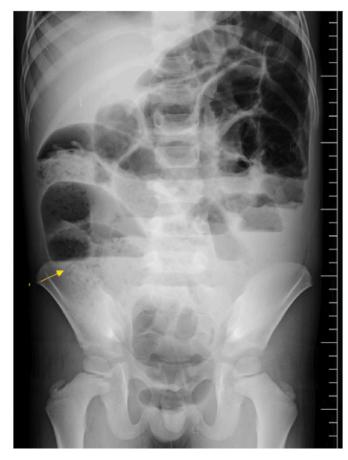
Multiple loops of dilated bowel can be seen throughout the abdomen on abdominal radiography. Multiple air-filled tubular structures, mainly in the right lower quadrant, are also noticeable on abdominal radiography (Fig. 1).
